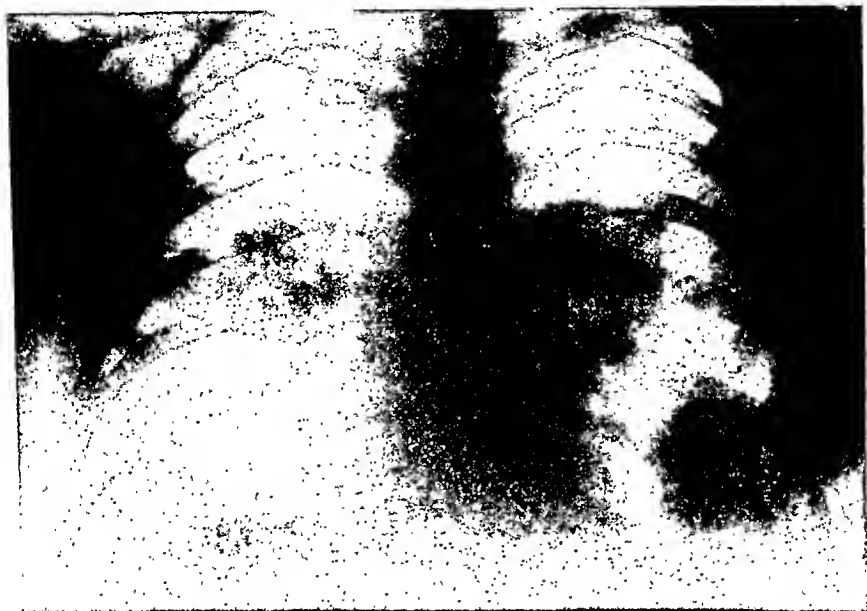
X-ray, taken Nov. 2, 1939, showing pulmonary metastases.
